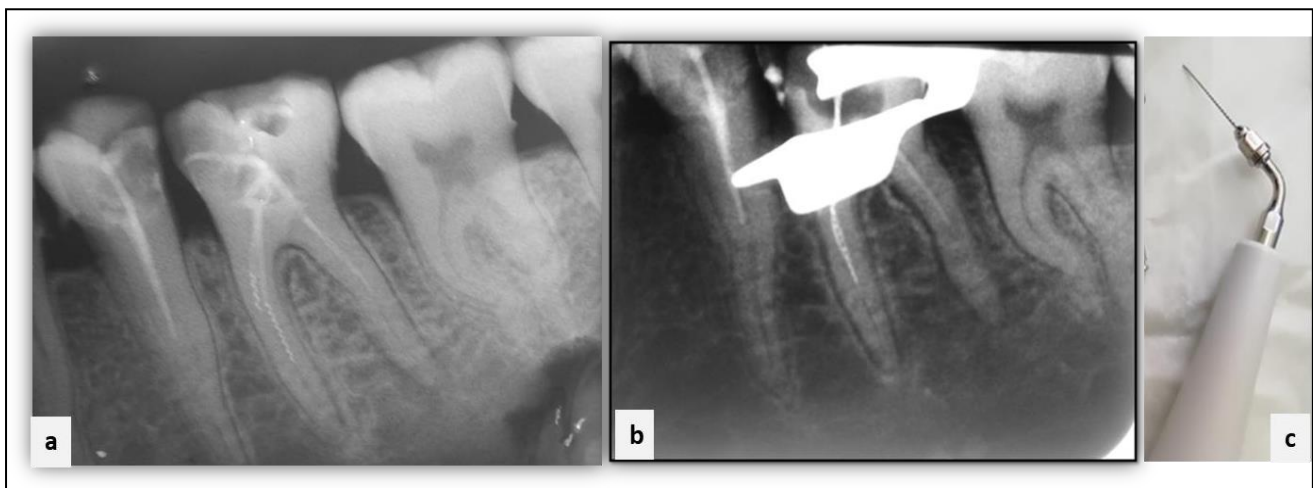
Pre-operative radiograph showing several separated instrument in tooth # 36.
